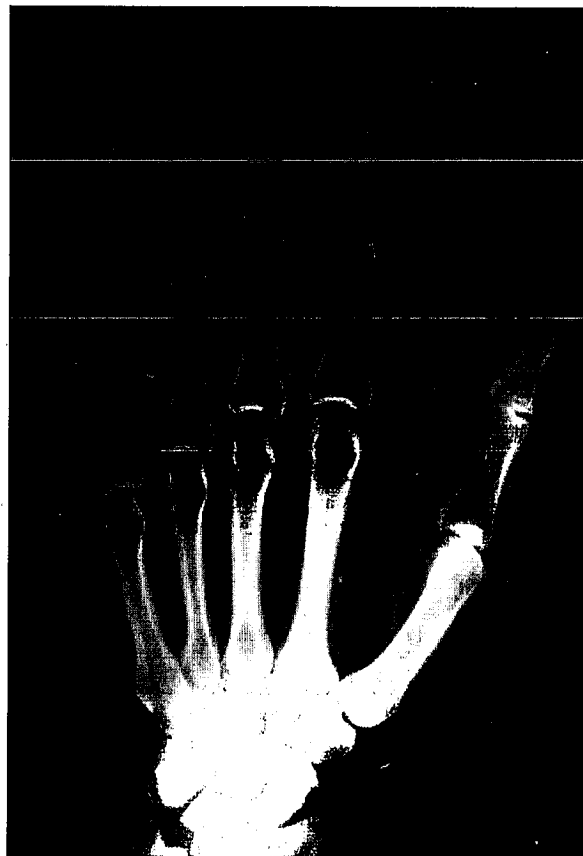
Radiograph showing calcification in the soft tissue adjacent to the thumb interphalangeal joint on the palmar side. The round ossification adjacent to the metacarpal phalangeal joint is a sesamoid bone.
